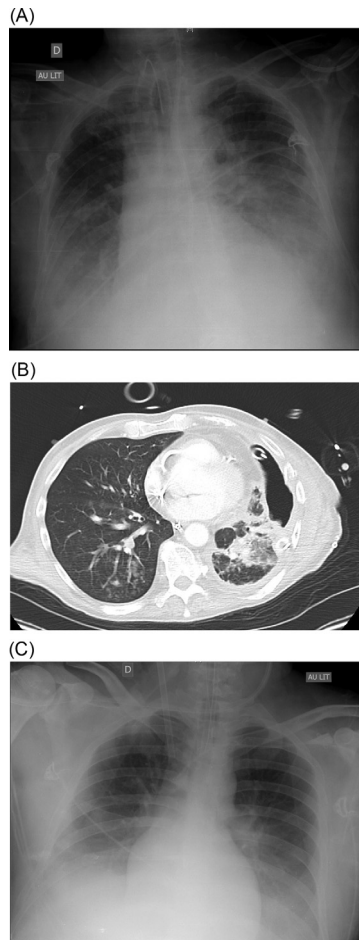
The radiological (chest radiographs and scans) patterns of HSV and CMV reactivation among ICU patients. (A) A 69 old man with suspicion of VAP with fever, gaz exchange worsening and chest radiograph infiltrates. BAL found no bacteria only positive CMV PCR. (B) A 62 years old man with history of bacterial pleuro-pneumonia and suspicion of VAP. CT scan found bilateral bronchiolar micronodules evocating pneumonia. Bacteriological culture of BAL performed without antibiotics was sterile. CMV PCR in blood and BAL was positive. (C) A 36 years old man with severe ARDS under VV-ECMO, fever and gaz exchange worsening. BAL culture found *S. aureus* and *K. pneumonia* but also throat, blood and BAL HSV reactivation and liver cytolysis.
